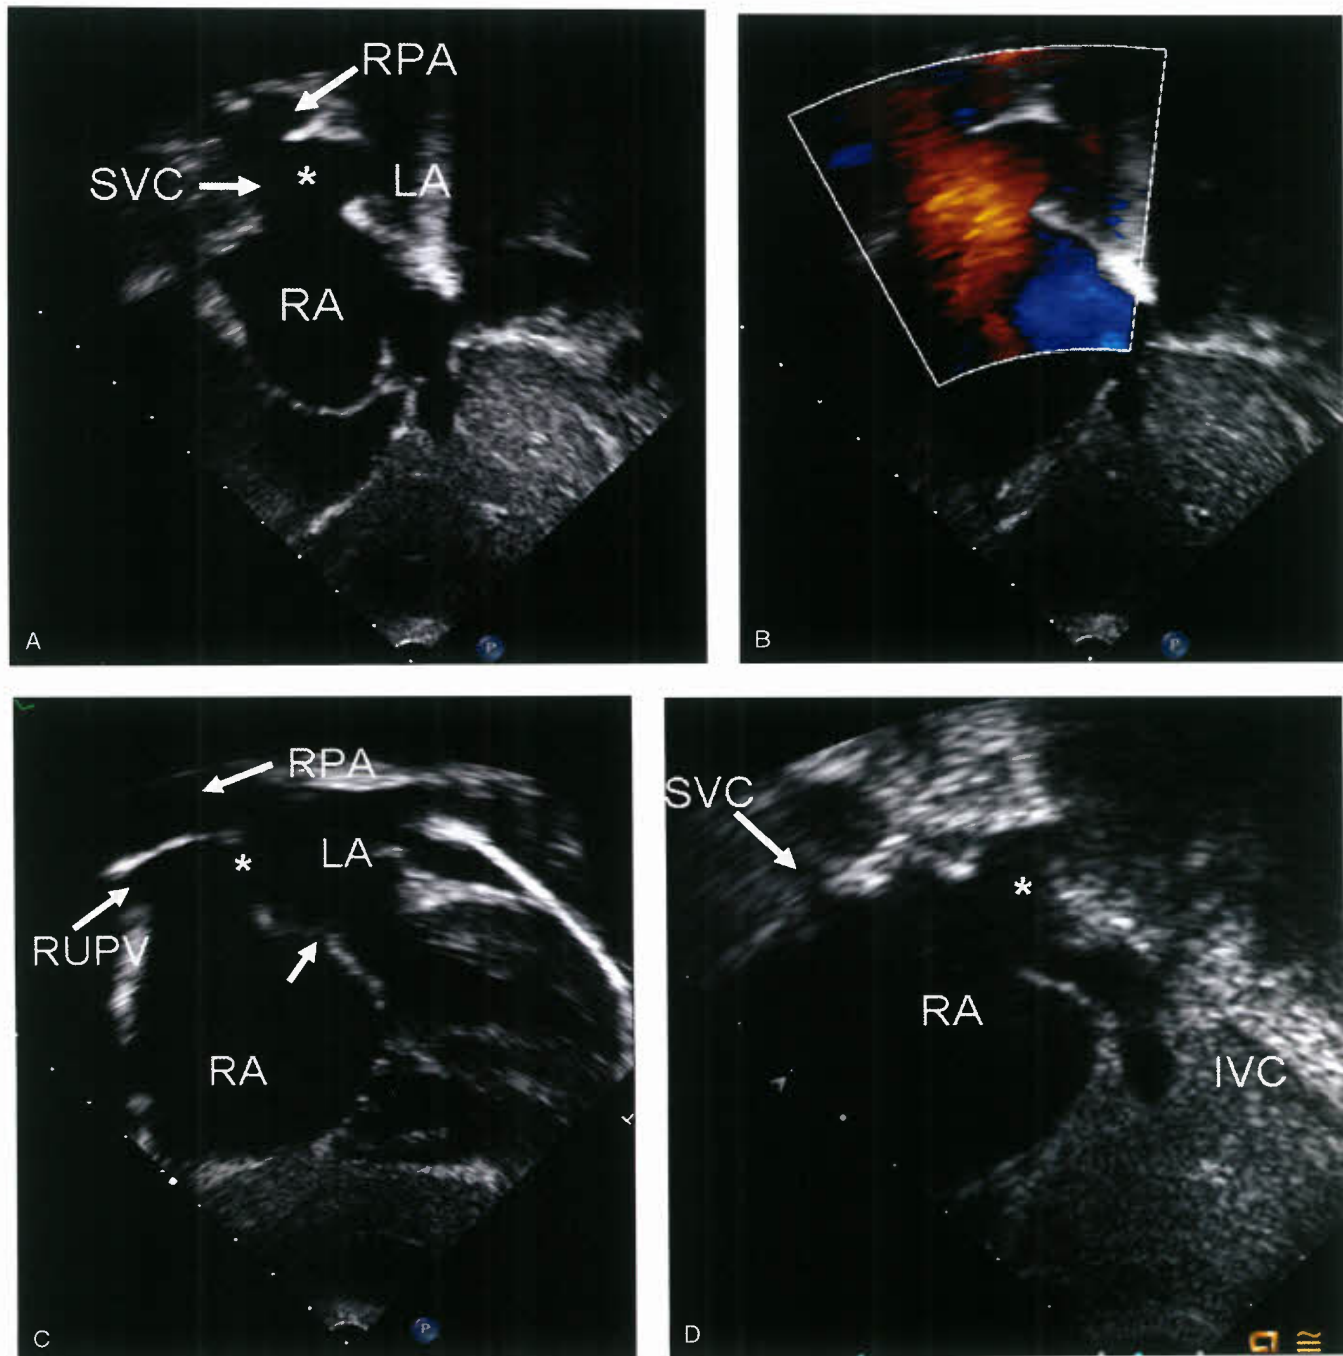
Echocardiography of sinus venosus defects: A: Subcostal sagittal view showing the SVC-type sinus venosus defect. The defect (*asterisk*) is cranial to the superior limbic band of fossa ovalis and is in communication with the cardiac end of SVC. B: Color Doppler image of the same defect shows the blood directed from LA to RA via the left atrial orifice of the right upper pulmonary vein and the sinus venosus defect. C: Subcostal coronal view showing the SVC-type sinus venosus defect (*asterisk*), the superior limbic band of fossa ovalis (*arrow*), and orifice of the right upper pulmonary vein (RUPV). D: Subcostal coronal views of right atrial type of sinus venosus defect (*asterisk*) showing a large defect in the posterior right atrial wall. IVC, inferior vena cava; LA, left atrium; RA, right atrium; RPA, right pulmonary artery.
